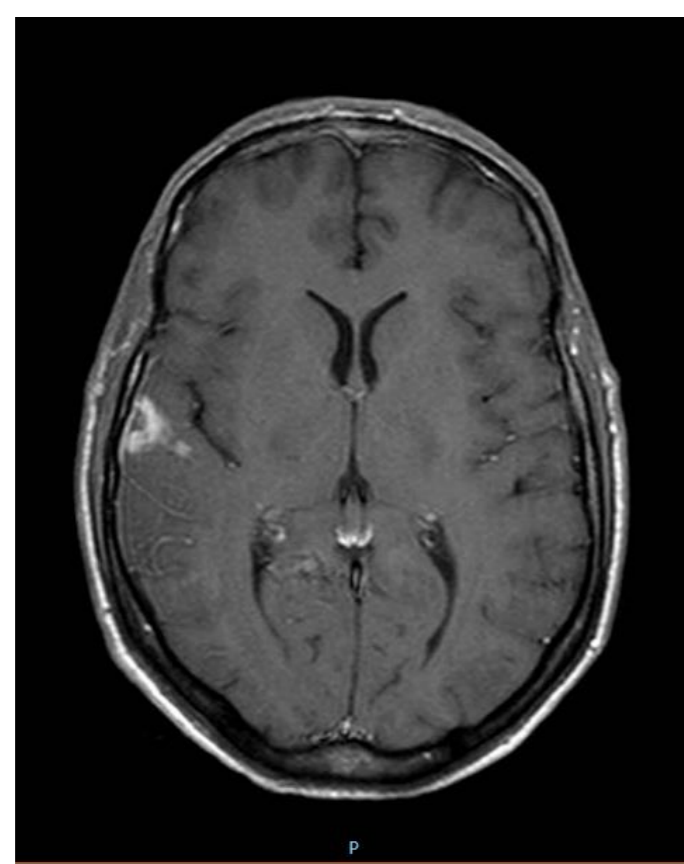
MRI T1 GD, axial scan
